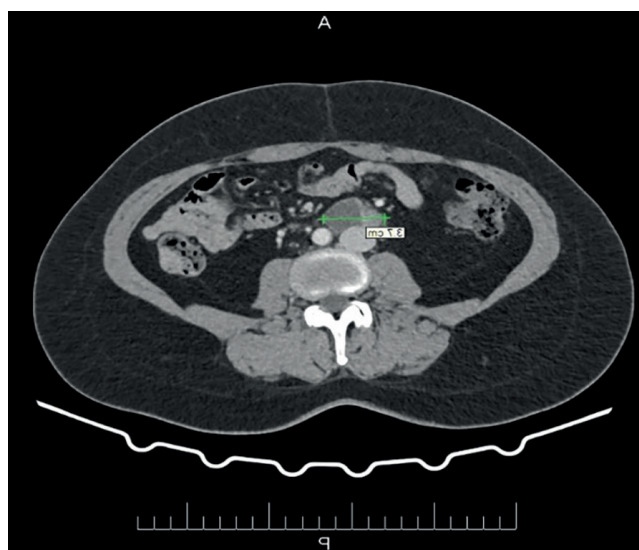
CT images of precaval retroperitoneal PEComa (transversal slide)
